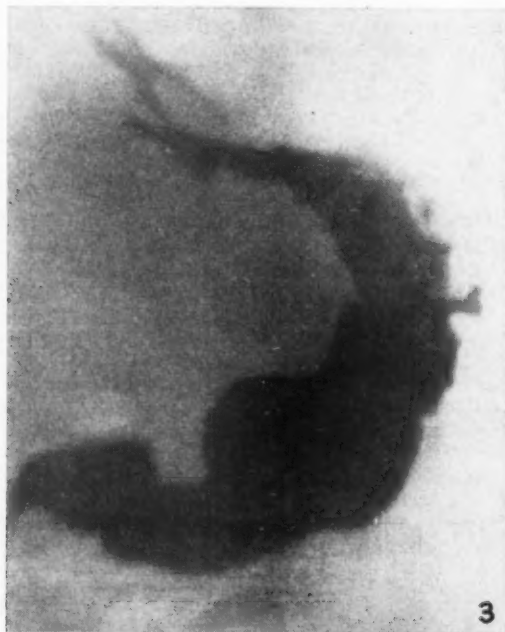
Barium meal X-ray. There is a slight irregularity of the lesser curvature of the stomach, but no sign of an ulcer crater to be seen.
